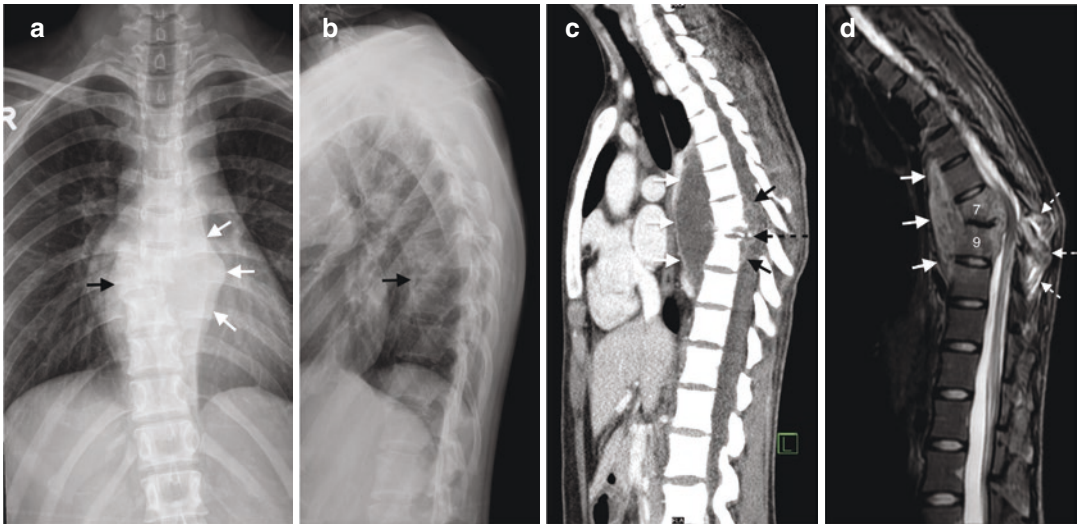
Tuberculous spondylodiscitis. (a) AP and (b) lateral radiographs of the thoracic spine show the right lateral remnant of a severely compressed and largely destroyed T8 vertebral body (black arrow), loss of the normal intervening T7/8 and T8/9 disc spaces, as well as a large associated paravertebral mass (white arrows). (c) Sagittal contrast-enhanced CT image better shows the severely compressed T8 vertebral body with small retro-pulsed bony fragments (black dotted arrow). Large anterior prevertebral abscess (white solid arrows) and epidural
